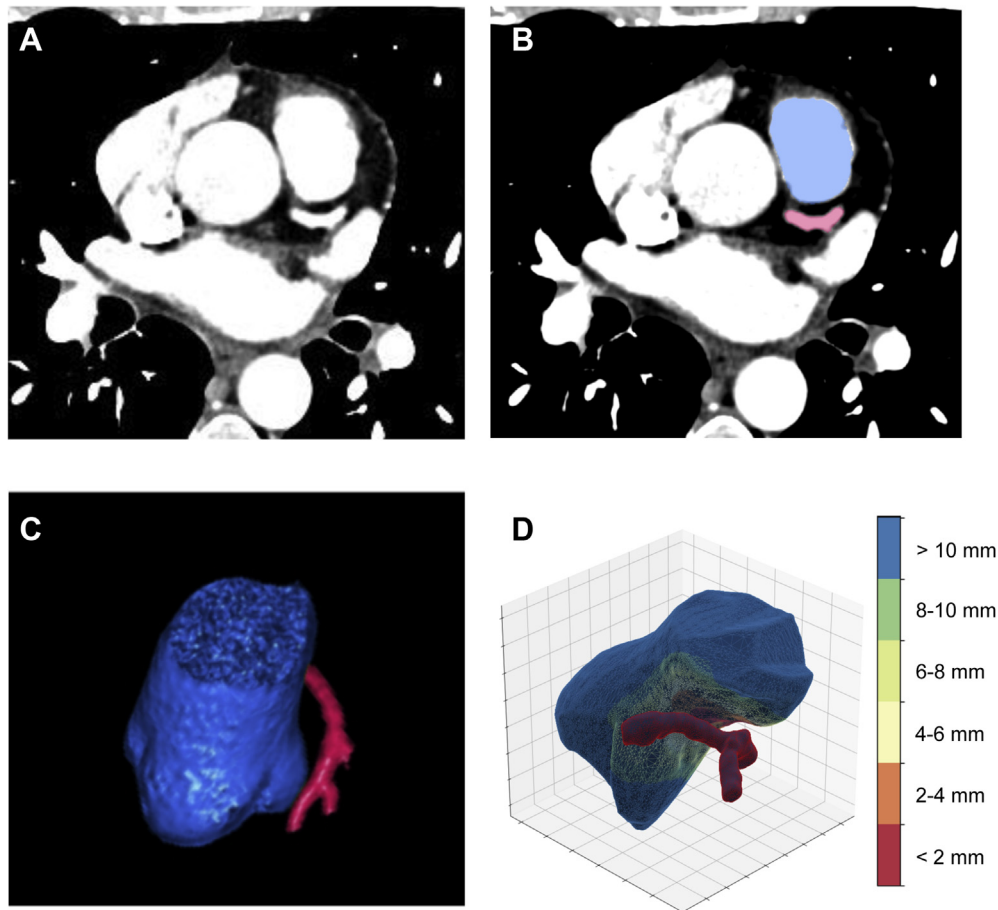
Generation of 3-dimensional anatomic models. Based on contrast-enhanced computed tomographic images (A), the proximal part of the pulmonary trunk and the left coronaries was carefully segmented (B). C: Three-dimensional models based on volume rendering were then transferred to a newly developed software tool in order to automatically determine the minimal distance to the coronaries. D: The close spatial relationship is demonstrated exemplarily with red marking areas of minimal distance and blue marking areas of wide distance.
